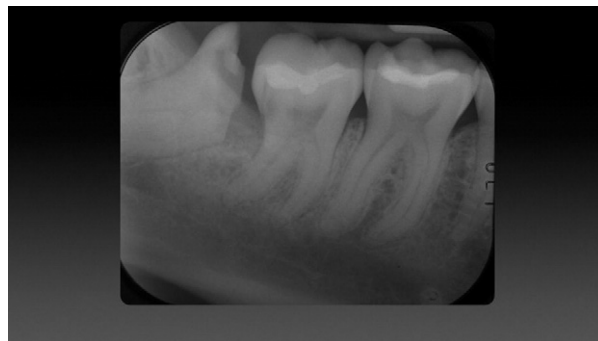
Postoperative radiograph after second section of the right mandibular third molar. A pulpotomy has been carried out. More space is created distal to the right mandibular second molar to allow further migration.
